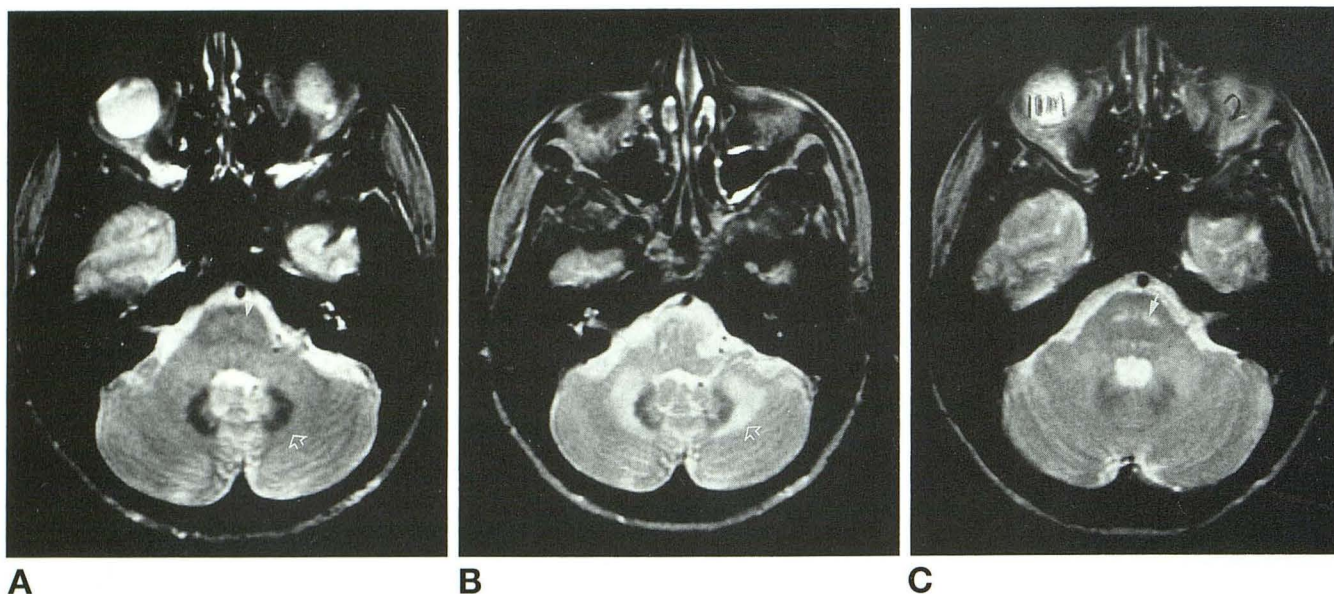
Patient 2, peridentate and pontine change. Axial T2-weighted acquisitions (2000/80) at the level of the middle cerebellar peduncles.
